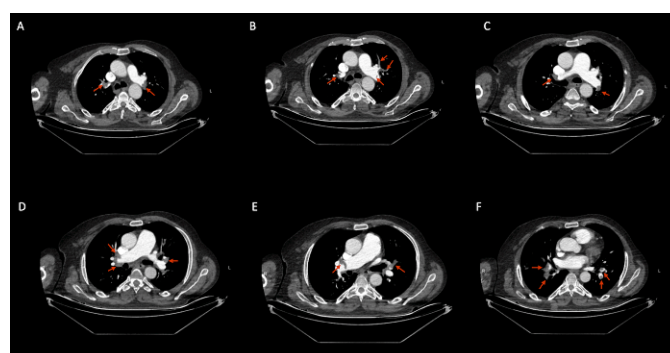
Massive pulmonary embolism in a 62-year-old man (In a 62-year-old male patient, filling defects consistent with pulmonary embolism in the right pulmonary artery, left pulmonary artery, lobar and segmental branches in axial sections of computed tomography angiography are shown with arrows).
